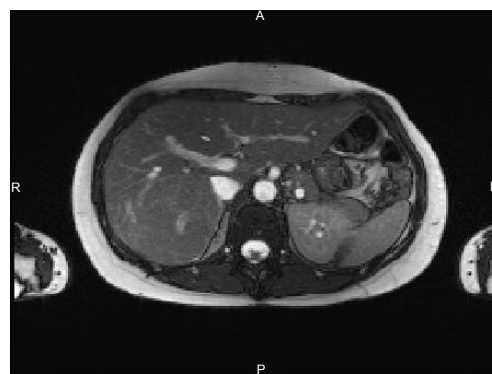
MRI T2, IVC below the level of the tumour.
